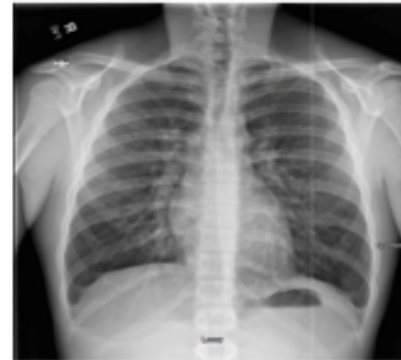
Our patient's chest x-ray showed parabranchial thickening consistent with viral vs reactive process, but no pneumonia or mass.
